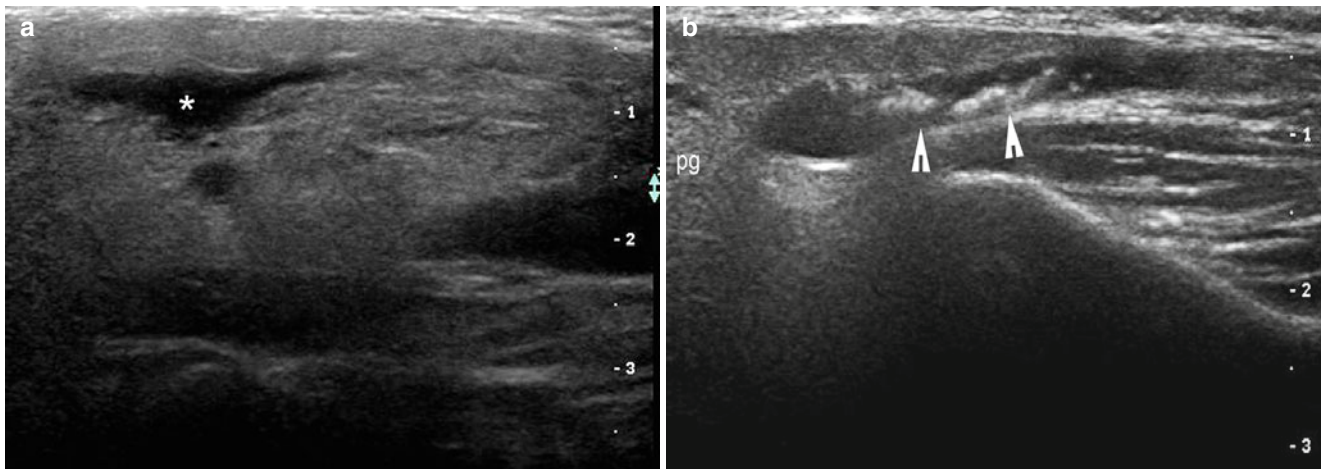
(a, b) Sialadenitis, ductal ectasia and stones of the parotid gland. (a) Grey scale ultrasound image (longitudinal view) demonstrates enlargement and ductal ectasia (*) of the right parotid gland.
